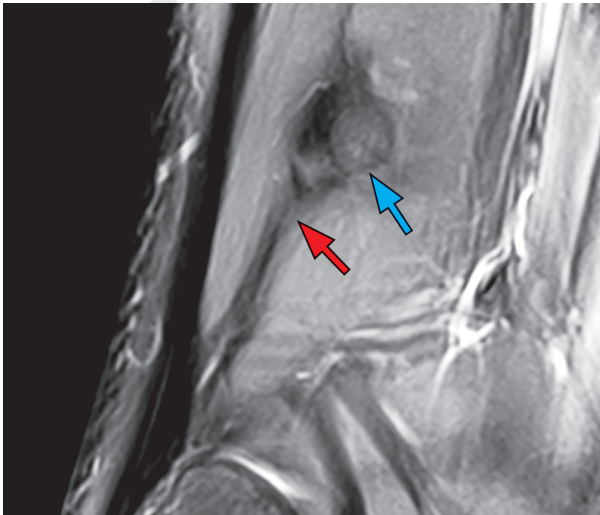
Fabellofibular ligament (blue arrow) on a coronal T1-weighted image, extending from the fabella to the fibula (red arrow).
